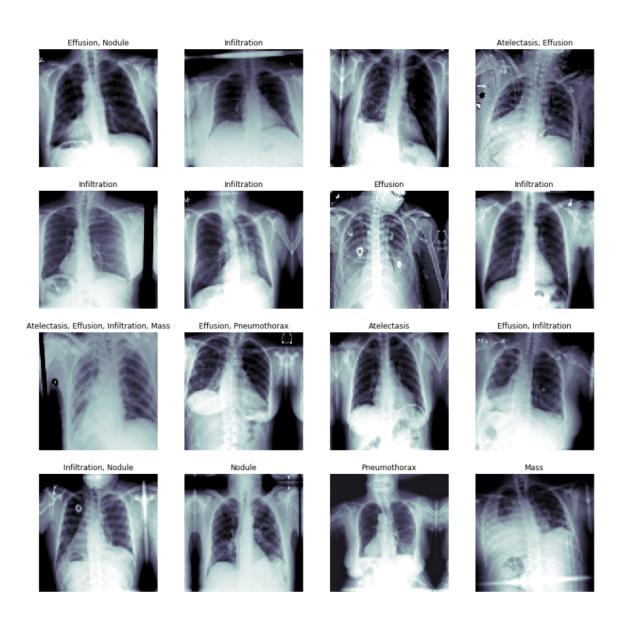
X-ray Image Recognition and Classification
